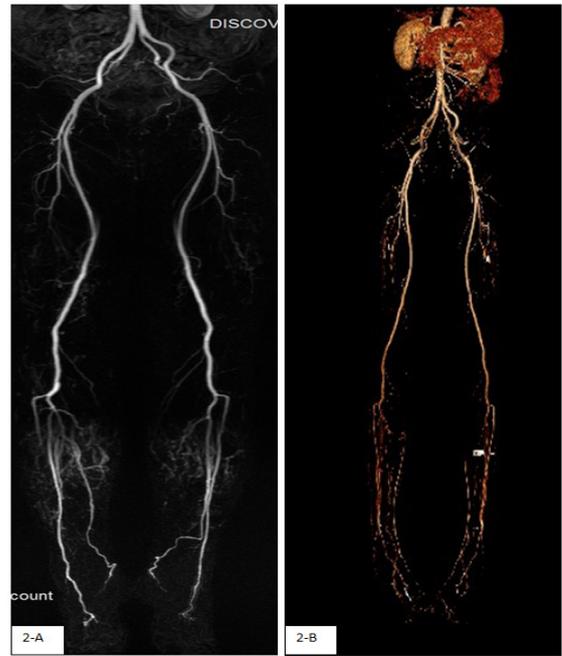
2-A, MRA of Lower Extremity Vessels; 2-B, CTA of Lower Extremity Vessels. MRA and CTA showed beadlike changes in the branches of lower extremity arteries, as well as obvious branches of lower leg arteries.
